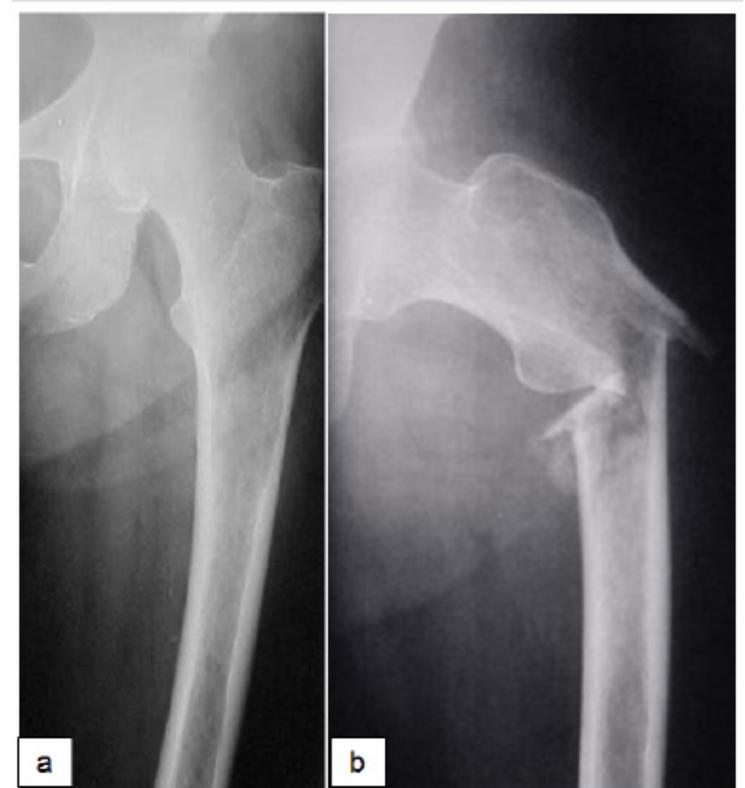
Lytic lesion can be missed in plain film until bone destruction leads to a pathologic fracture, as in this case of a moth-eaten pattern of bone destruction. Unrecognized pathologic fracture may delay diagnosis of the primary tumor. Courtesy from Dr. Walter Meohas from Trauma and Orthopaedics National Institute.
